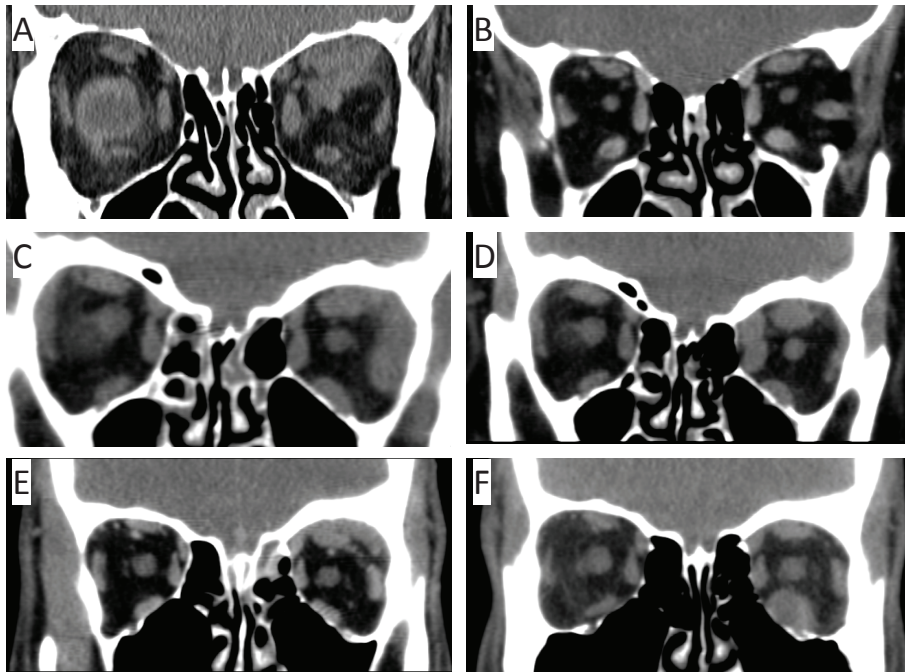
Computed tomographic coronal scans of the study patients. A, Patient 1: idiopathic orbital inflammation (IOI) of the left posterior superior orbit. B, Patient 1: 5 years later, bilateral extraocular muscle enlargement in Graves ophthalmopathy (GO). The mass in the left orbit has disappeared. C, Patient 2: dacryoadenitis of the left orbit. D, Patient 2: 4 months later, left-sided extraocular muscle enlargement in GO. The dacryoadenitis has resolved itself. E, Patient 4: IOI of the left superior orbit. F, Patient 4: 5 years later, extraocular muscle enlargement in GO. The mass in the left superior orbit has disappeared.
